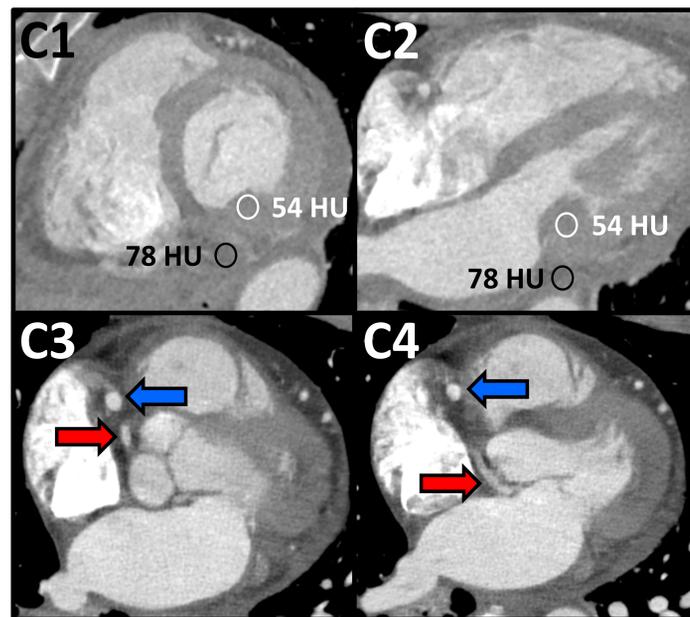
CT in short (C1) and parasternal long axes (C2) demonstrating radiodensity difference between vegetation and myocardium; anomalous LCx (red arrow) with posterior takeoff of RCA (blue arrow) and retro-aortic course (C3,C4).
